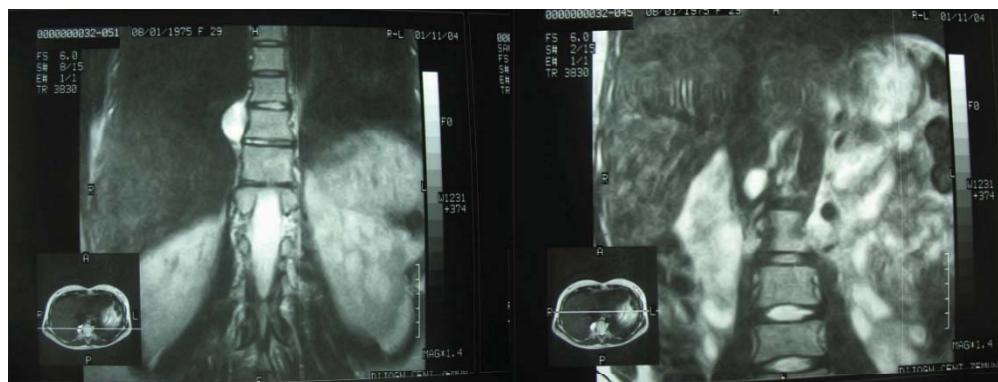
Thoracic magnetic resonance image (MRI) demonstrated lesion in the right paravertebral region in the level of Th 10 vertebra. Abdominal MRI demonstrated lesion behind the right renal vein, laterally from the *v. cava inferior*
